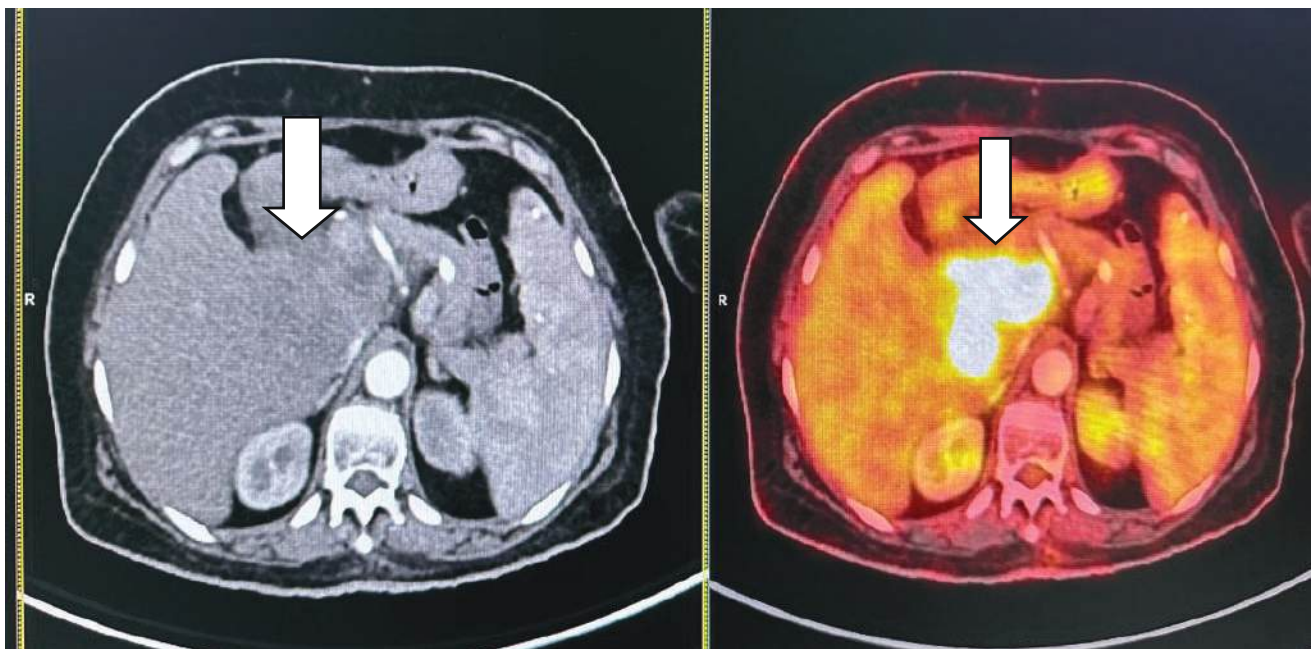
Hepatic metastasis from primary breast cancer. Intense FDG avid (SUV: 15.90) enhancing lesion noted at caudate lobe of liver (white arrow).
